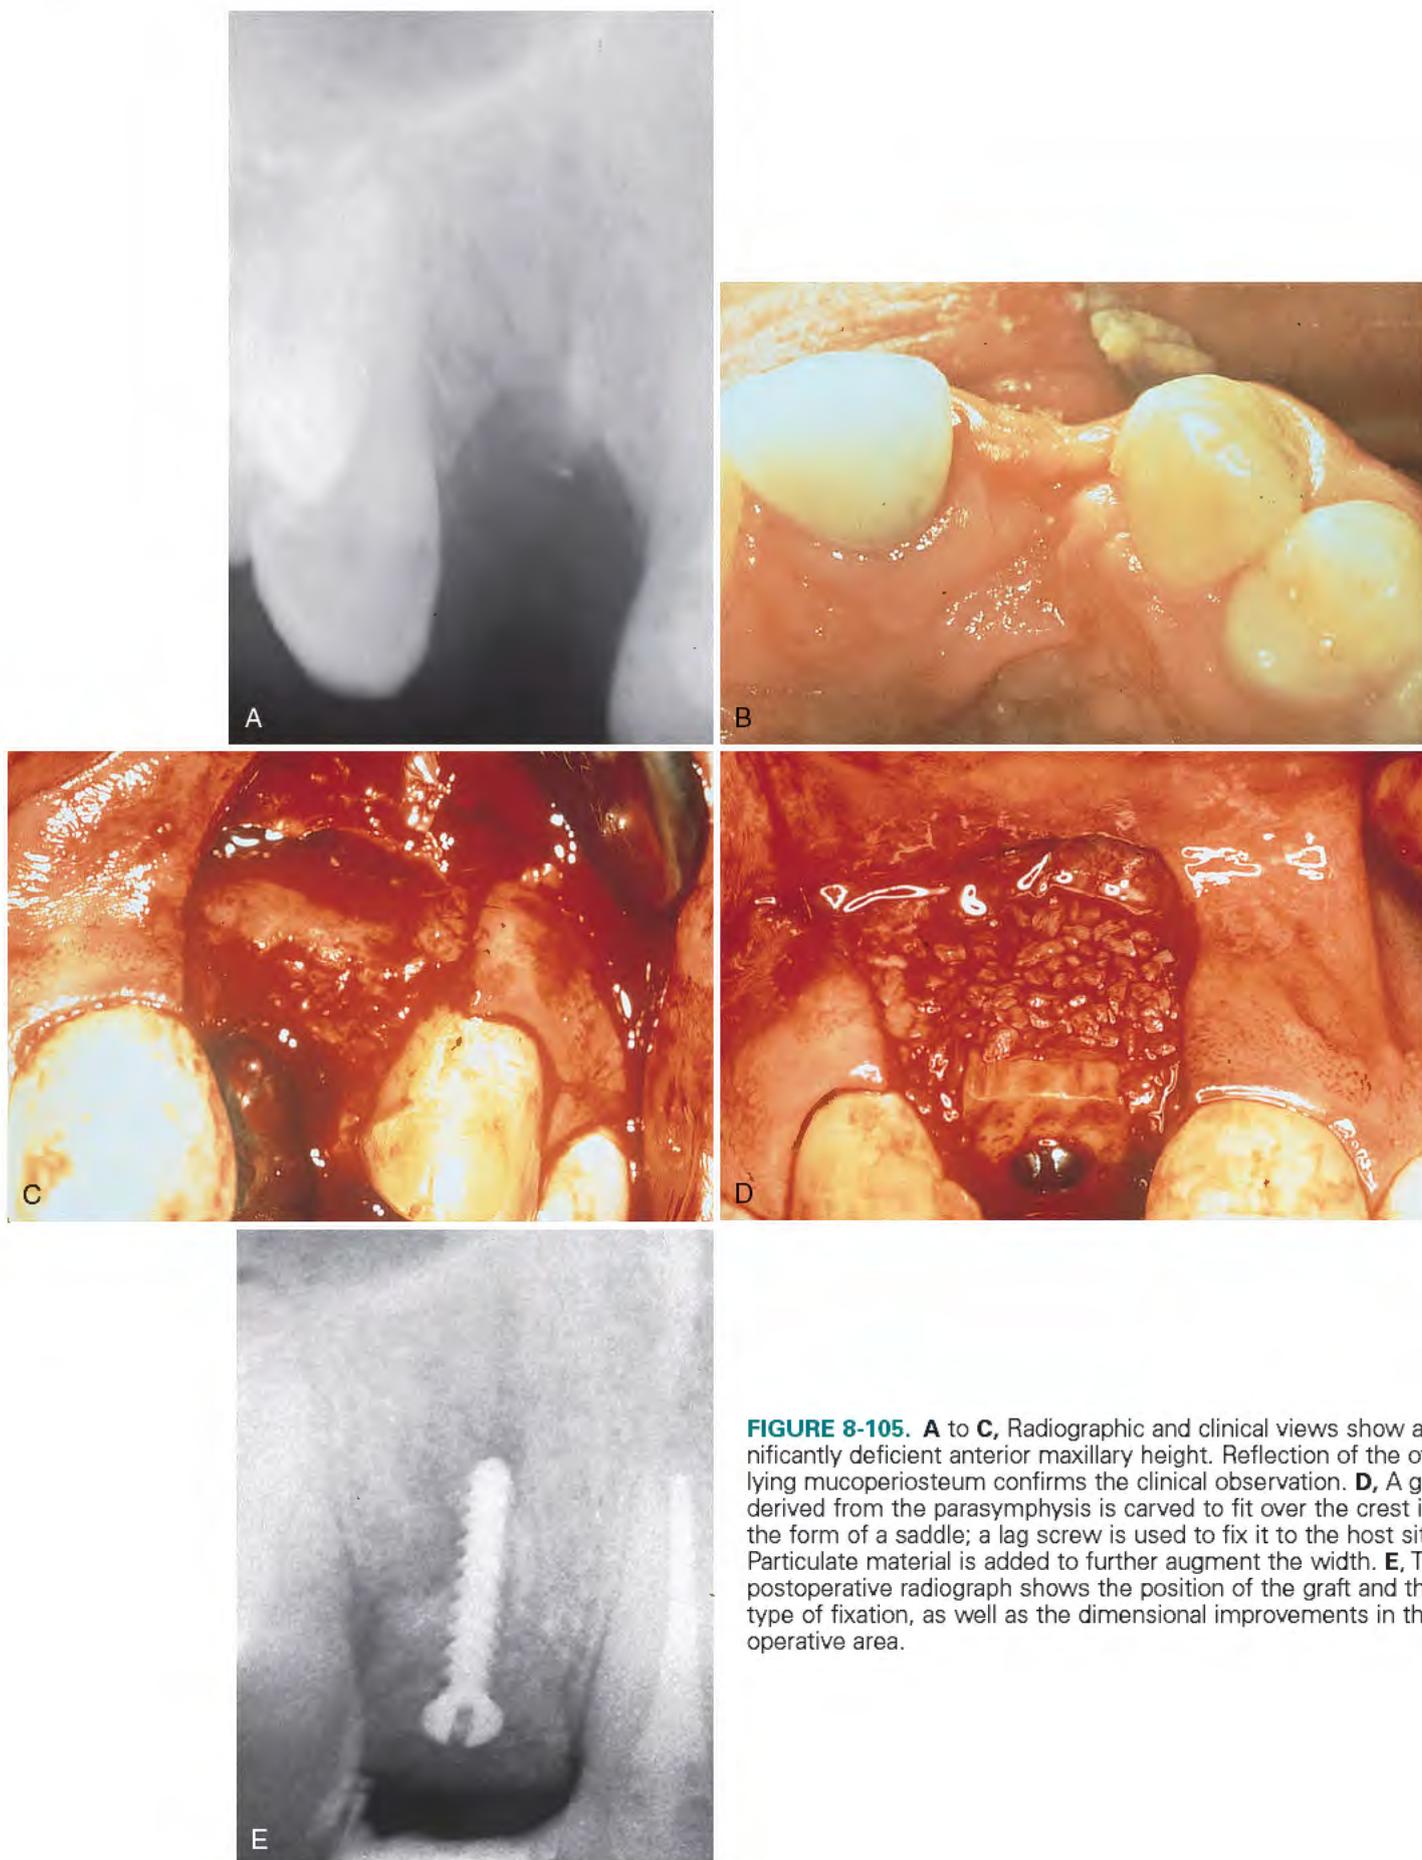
A to C, Radiographic and clinical views show a significantly deficient anterior maxillary height. Reflection of the overlying mucoperiosteum confirms the clinical observation. D, A graft derived from the parasymphysis is carved to fit over the crest in the form of a saddle; a lag screw is used to fix it to the host site. Particulate material is added to further augment the width. E, The postoperative radiograph shows the position of the graft and the type of fixation, as well as the dimensional improvements in the operative area.
